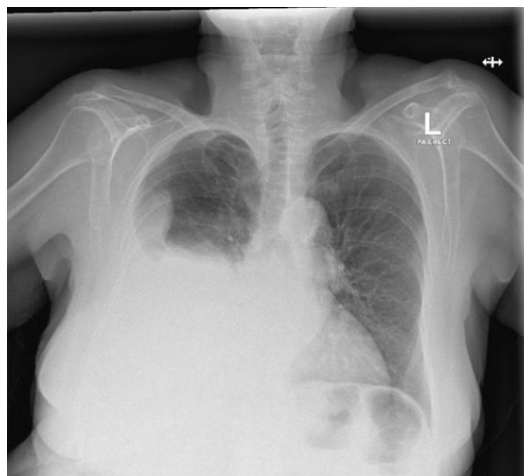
Chest radiograph showing large right pleural effusion.
